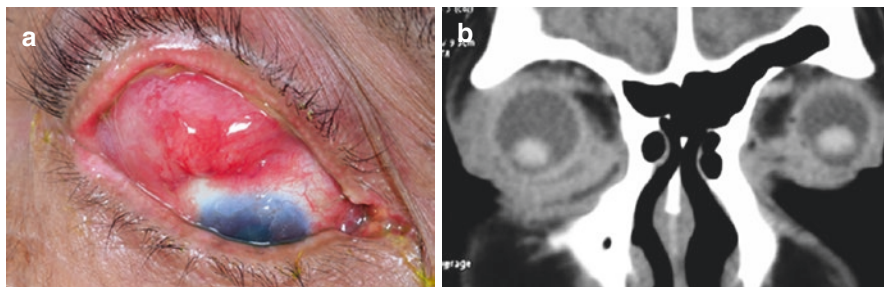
Orbital secondary tumors. (a) A 59-year-old male with recurrent conjunctival squamous cell carcinoma right eye. (b) Coronal CT orbit shows diffuse right orbital involvement by extension of the conjunctival tumor
